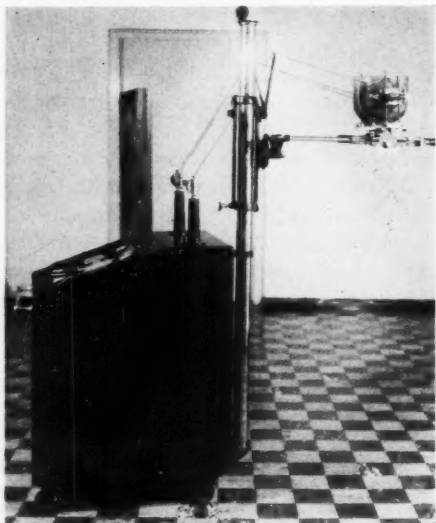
Mobile x-ray therapy unit.
